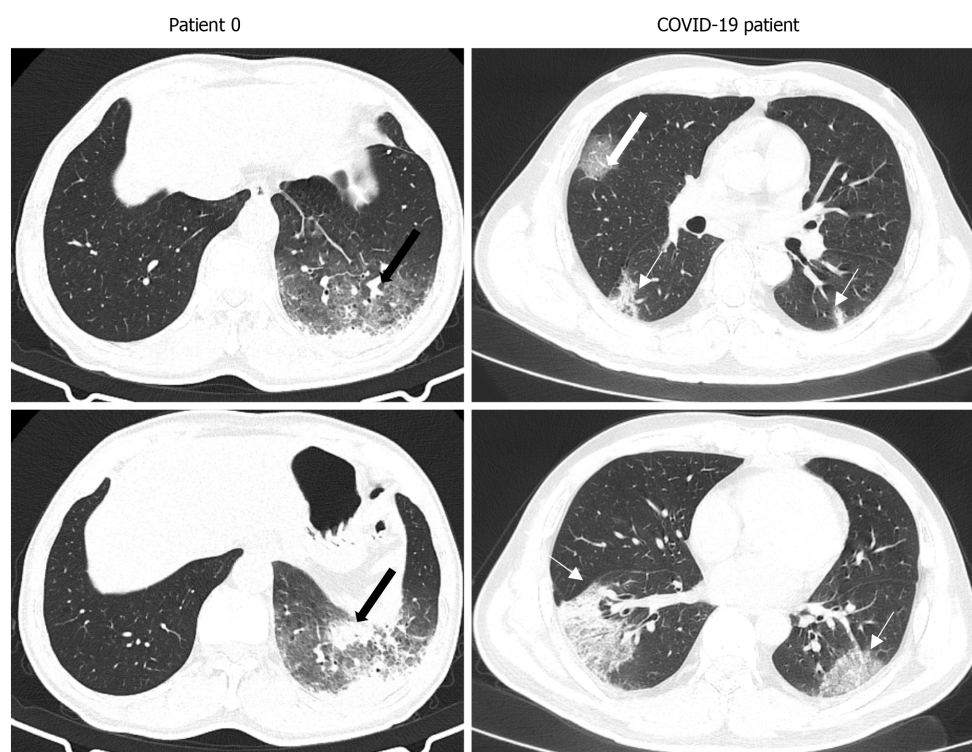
The computed tomography image finding of patient 0 and a case of coronavirus disease 2019. The patient 0 have similar imaging findings (mixed ground-glass opacity and consolidation) to patients 1-4 (black thick arrow). The patients of coronavirus disease 2019 (COVID-19) presented multifocal and bilateral ground-glass opacity (white thin arrow) and vascular enlargement (white thick arrow). The margin of lesions in patients with COVID-19 is clearer. COVID-19: Coronavirus disease 2019.
